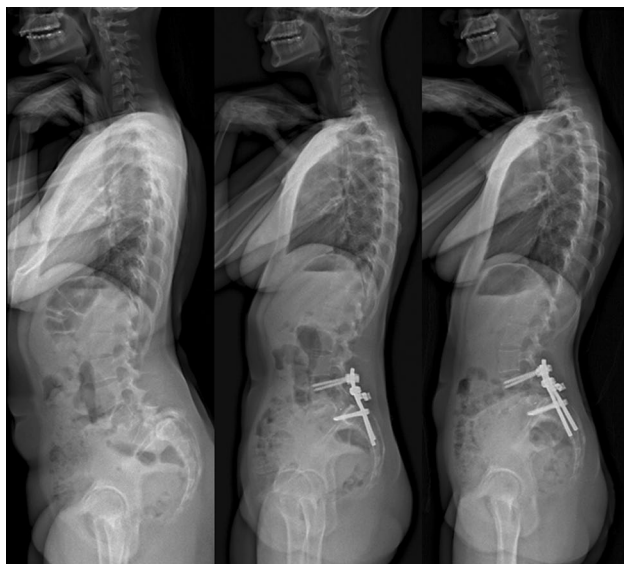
Sagittal X-rays of HGS patient pre-, postoperatively and at last follow-up
